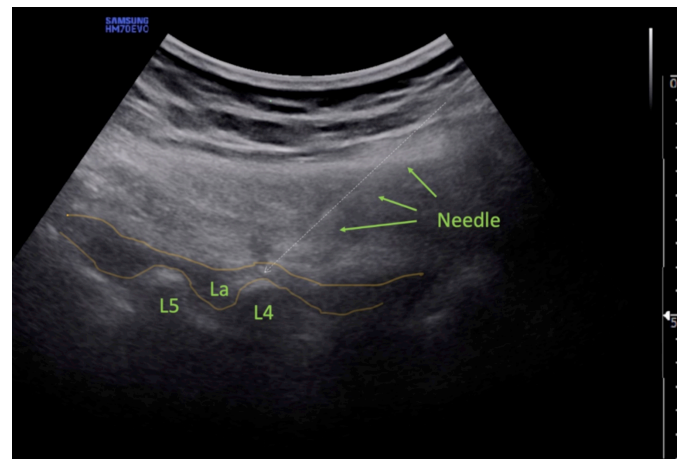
Ultrasound image of lumbar erector spinae plane block performance showing the needle, L4 and L5 lumbar vertebrae, and the distribution of local anaesthetic solution (La).
